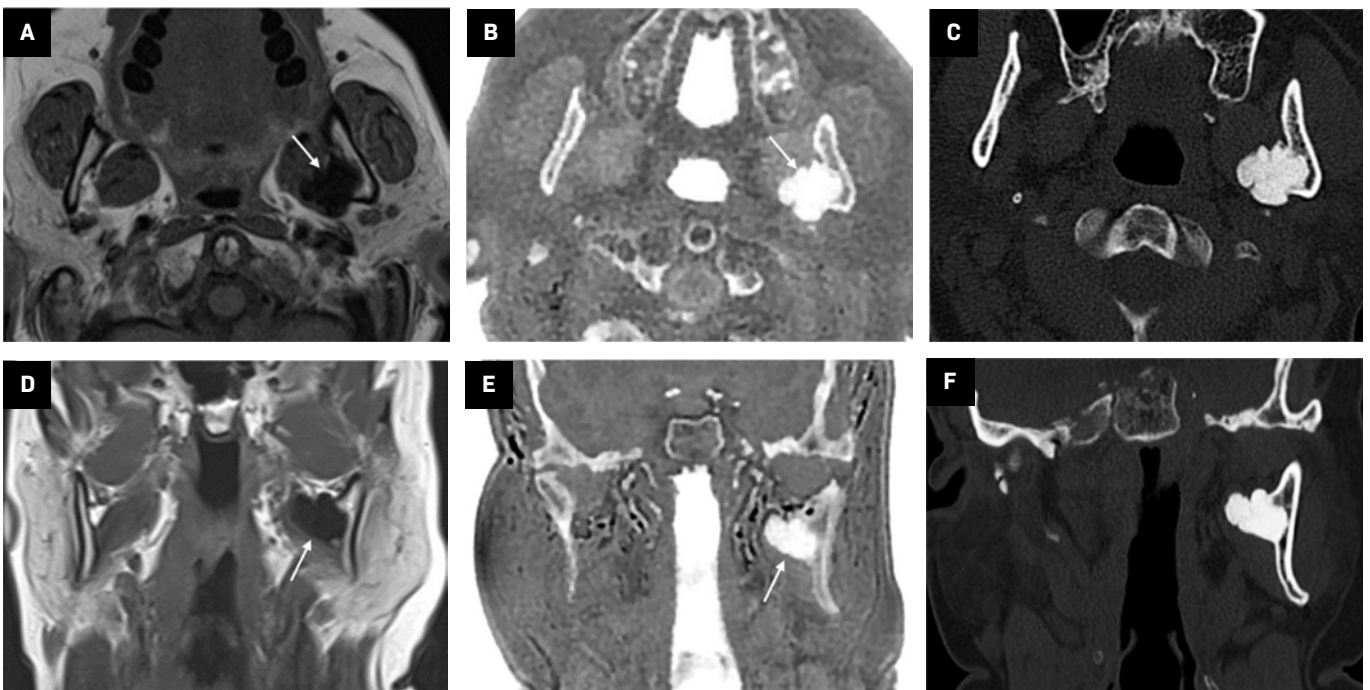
Axial (A) and coronal plane T1 (D) MR images show a low-signal lesion adjacent to the left mandible ramus (arrows). Axial (B) and coronal plane (E) zero-echo-time (ZTE)-grayscale inversion images show that the lesion originates from the ramus of the mandible. Axial (C) and coronal plane CT (F) images show similar features to the ZTE images and clearly show that the mass originates from the mandibular ramus. The lesion was diagnosed as an osteoma.
